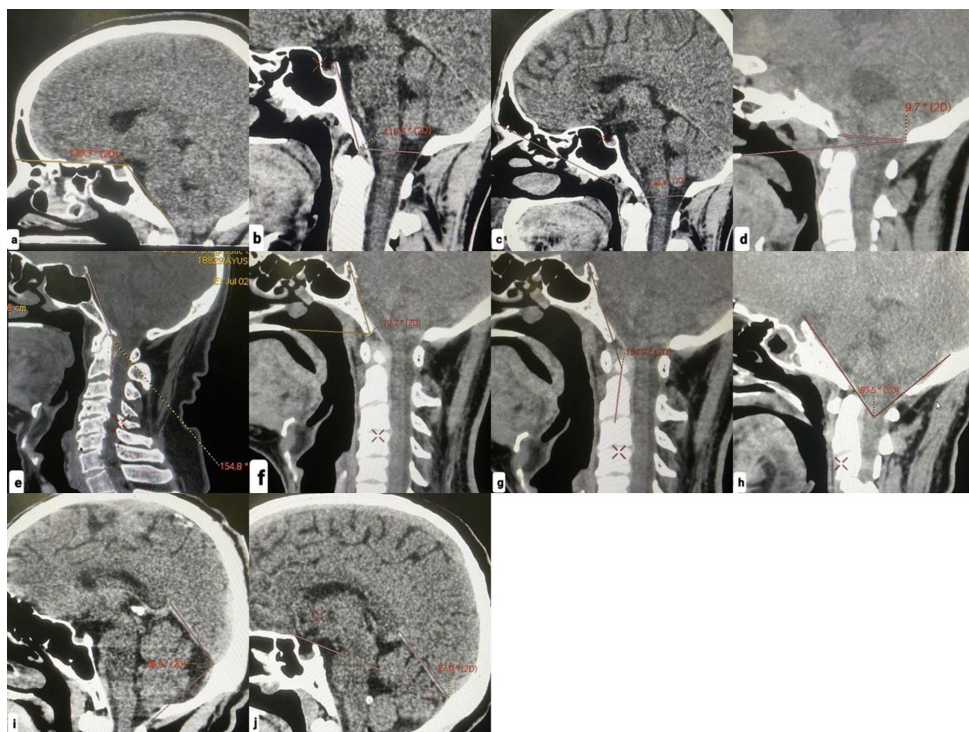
Mid-sagittal reconstructed images of computed tomography scan of the posterior fossa and the craniovertebral junction demonstrating the various angular radiometric parameters. a Basal angle; angle between line connecting the nasion to the tip of the dorsum sellae and line extending from the tip of the dorsum sellae to the tangential surface of clivus. b Boograd angle; Angle between line connecting the tip
